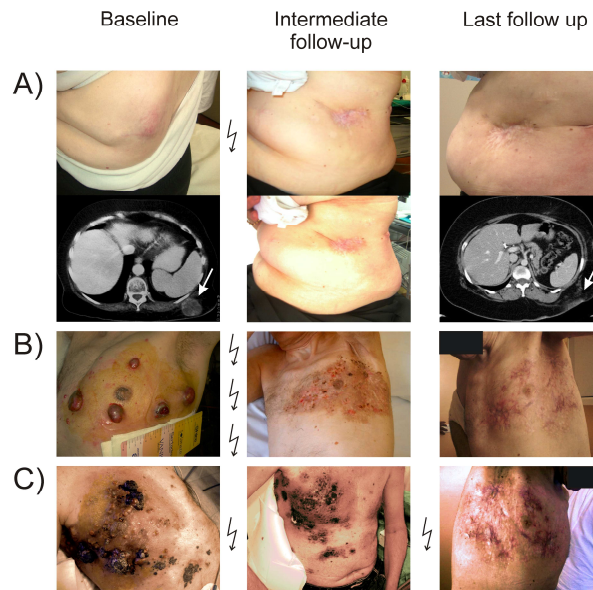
Cutaneous metastases in three patients treated with electrochemotherapy (ECT). a Large subcutaneous recurrent metastasis of the chest wall in a patient previously treated with wide surgical excision (left panel; baseline computed tomogram shown below). A complete response was observed 2 months after a single ECT session. Intermediate clinical follow-up was at 6 months (centre panel). Additional cytotoxic chemotherapy and interferon therapy was administered for lung metastases after 18 months. The patient was disease-free at the last clinical and radiological examination at 42 months (right panel). b Disseminated lesions of the trunk at baseline (left panel). Treatment with ECT led to a partial response at intermediate follow-up at 1 month (centre panel). There was complete and long-lasting cutaneous remission after the second ECT cycle, and the patient was alive with disease at last follow-up after 37 months (right panel). c Multiple bulky lesions of the trunk at baseline (left panel). Treatment by three ECT cycles led to a complete response at intermediate follow-up after 12 months (centre panel) with superficial tumour control at 42 months (right panel). Each jagged arrow (⚡) represents a single ECT session.
